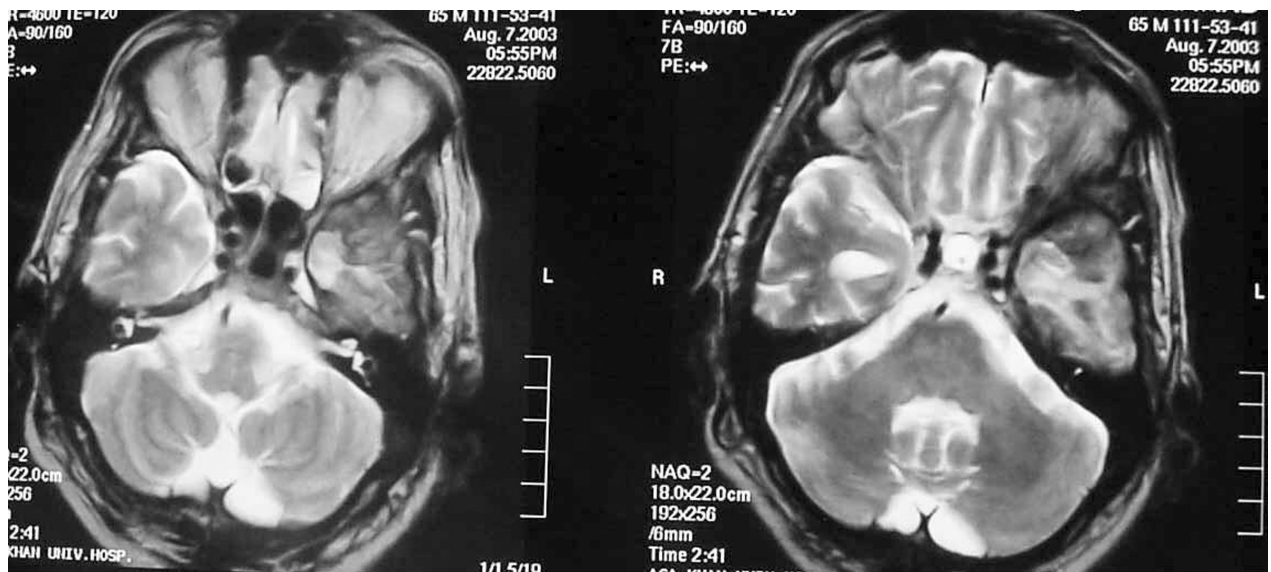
(a) T-2 weighted MR imaging (axial section) showing a hypo-intense mass lesion located in the temporal region, lying medially with extension on the lateral aspect of cerebral cortex saddled on the sphenoid ridge. (b and c) T-1 weighted Post-contrast imaging (axial and coronal sections) showed a significantly bright enhancement of the same mass lesion. There is also meningeal enhancement adjacent to the mass. Sphenoid sinus mucosa is thickened and showing enhancement
